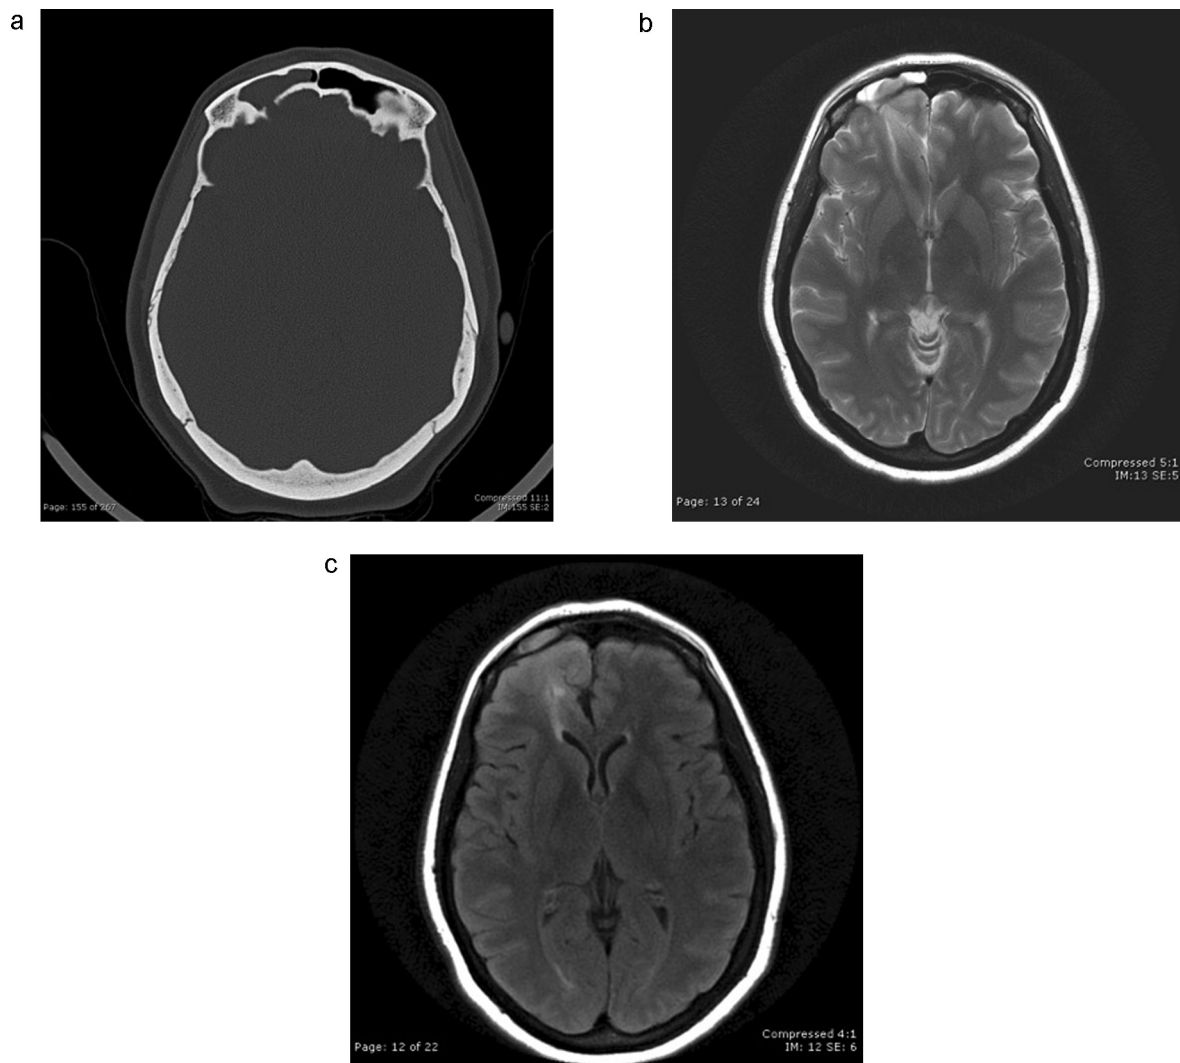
(a) CT of the head bone window demonstrating opacification of right frontal sinus and defect in posterior wall of right frontal sinus, (b) MRI T2 weighted image and (c) FLAIR image showing lesion within right frontal sinus isointense to cortex with right frontal lobe FLAIR abnormality.
